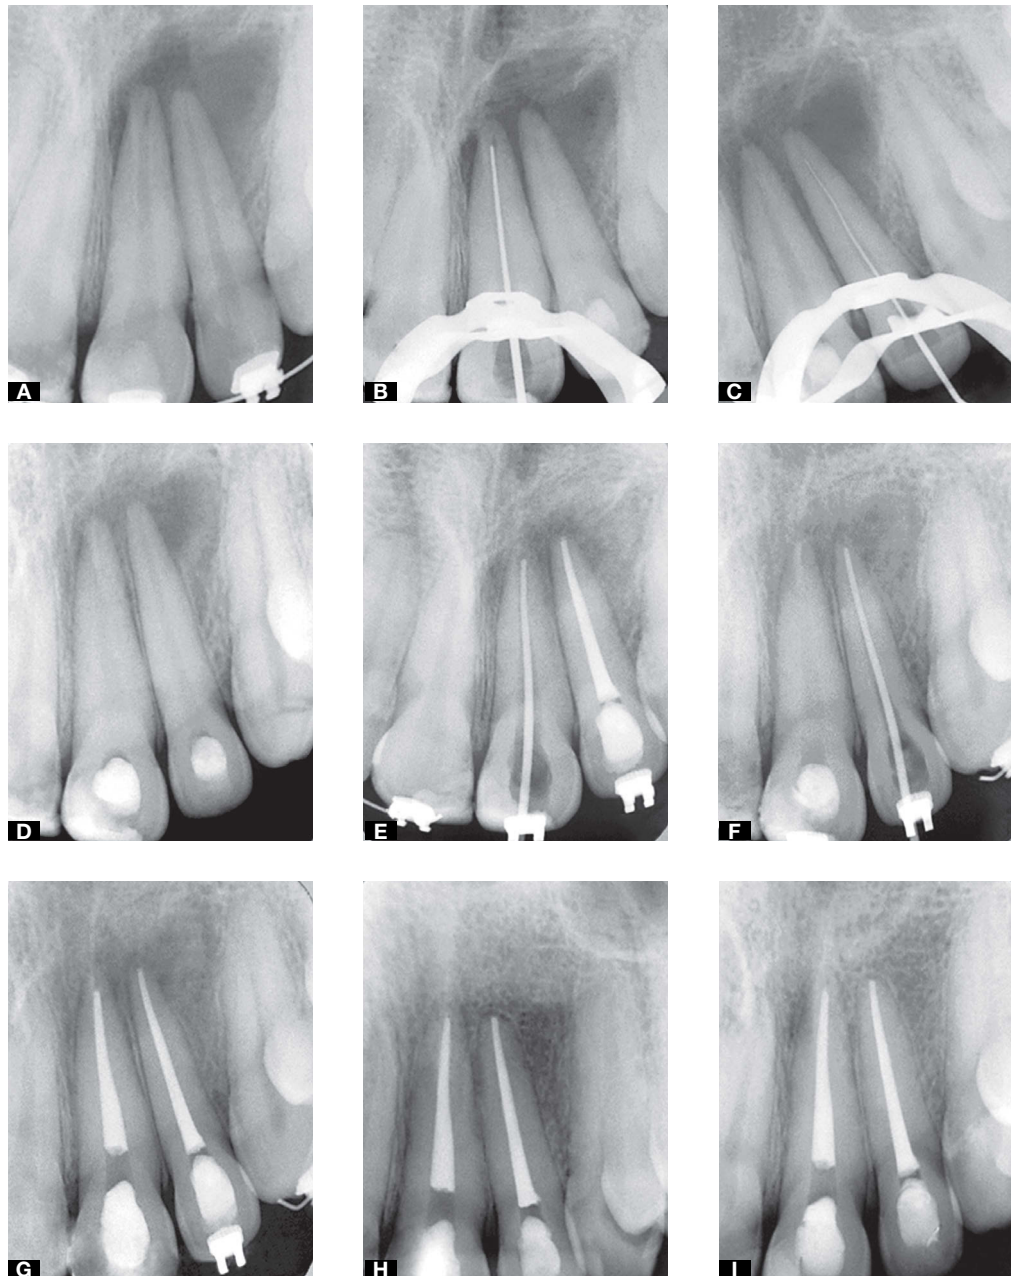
A) initial radiograph showing periapical radiolucency suggesting chronic abscess, (B) odontometry (tooth #21), (C) odontometry (tooth #22); (D) intracanal medication of calcium hydroxide paste with propylene glycol and partially reabsorbed, (E) gutta-percha points (tooth #22), (F) gutta-percha points (tooth #21), (G) root canal filling radiographs, (H) radiographs after three years of follow up, showing total periapical repair; (I) radiographs after six years of follow up, showing complete periapical repair.
